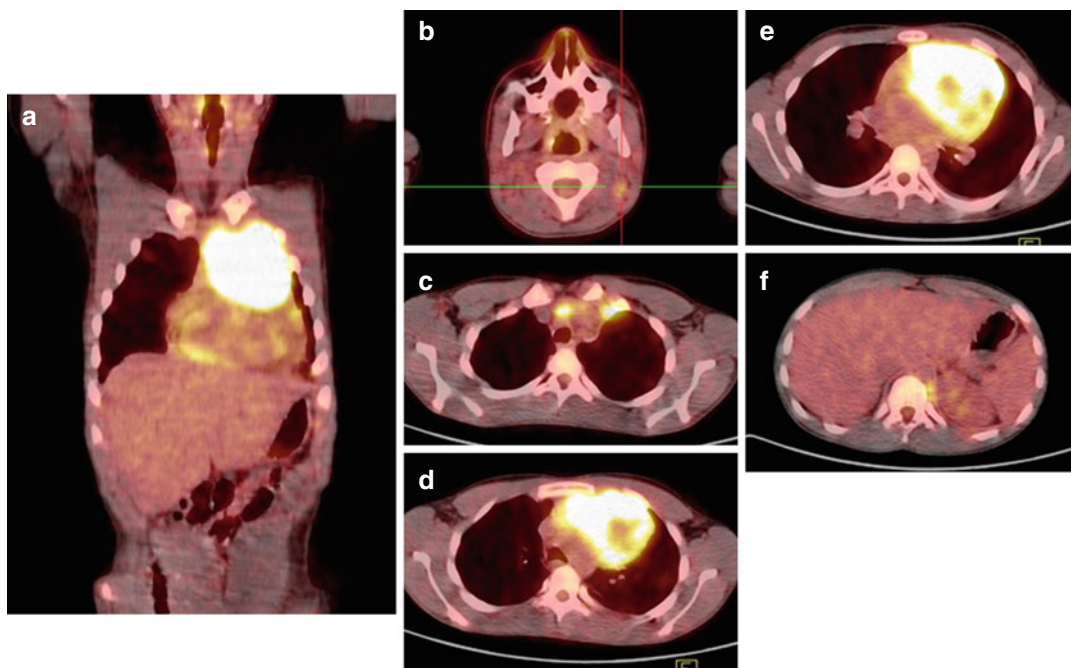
Fused FDG-PET/CT: Hypermetabolic lymph node mediastinal mass (a, c–e). Small hypermetabolic
